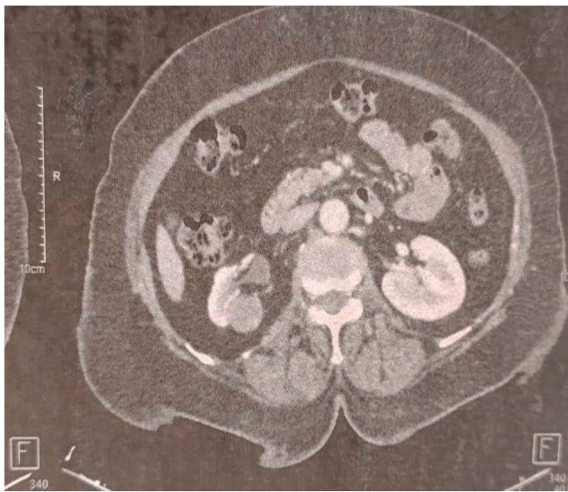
Abdominal computed tomography (CT) showed a well-defined 24 mm right mediorenal cyst with an irregular wall that enhanced after the injection of contrast material, along with thick, irregular calcifications classified as Bosniak 3.
